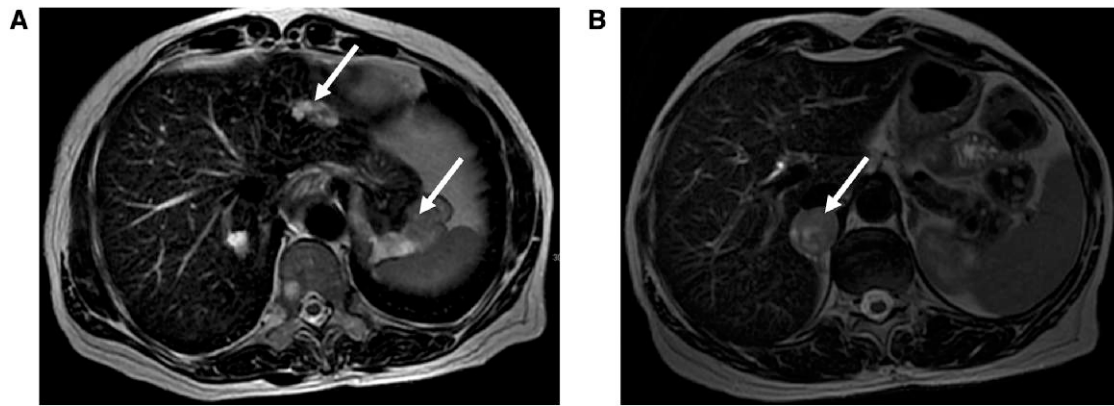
(A) Axial T₂-weighted magnetic resonance imaging (MRI) scan indicating an 8-cm GIST and a metastatic GIST liver lesion (white arrows). (B) Axial T₂-weighted magnetic MRI scan showing a 3-cm right pheochromocytoma (white arrow). GIST, gastrointestinal stromal tumor.
